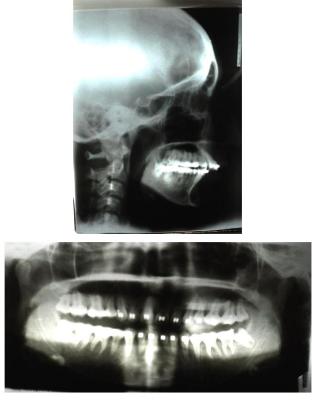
Pre Surgical Radiographs – Lateral Cephalogram and OPG
